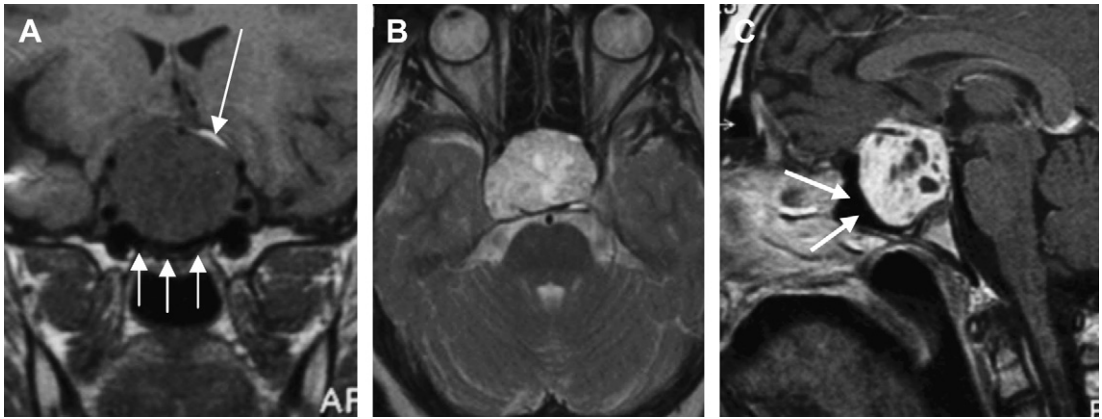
Coronal T1-weighted (A), axial T2-weighted (B) and gadolinium-enhanced sagittal T1-weighted (C) images show a rounded well-margined mass lesion, expanding the sella and growing into the suprasellar cistern. Note the inferior displacement of the sellar floor, almost collapsing the sphenoid sinus (*small white arrows in A and C*). The lesion is of intermediate signal intensity on T1-weighted and T2-weighted images with small T2-weighted hyperintense and nonenhancing cystic areas. Also, note a thin spontaneously hyper-intense rim on the coronal T1-weighted image suggesting marginal calcification (*long white arrow in A*) (craniopharyngioma).
